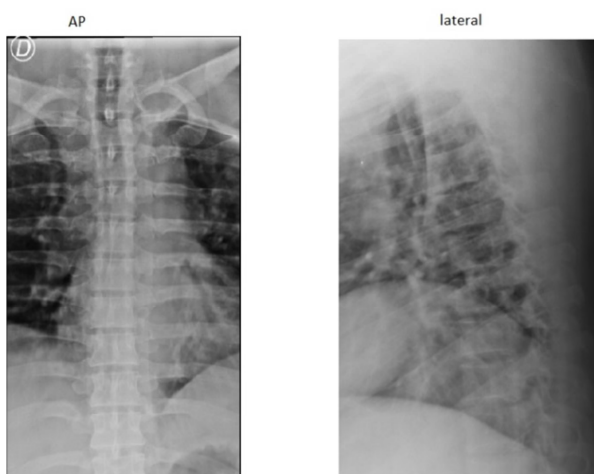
Spine x-ray showed an upper plate fracture at L1 vertebrae with 33% loss of height.
